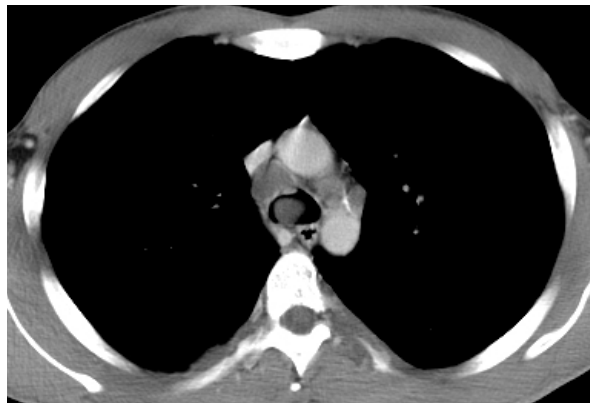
Computed tomography revealed an exophytic nodule at the membranous portion of the lower trachea
